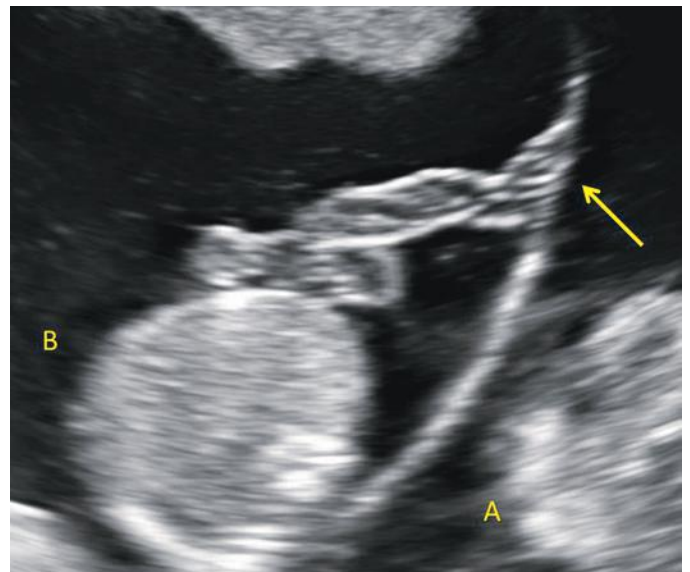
Two-dimensional ultrasound image demonstrates a velamentous cord insertion (*arrow*) of twin B, directly into the separating inter-twin membrane.
